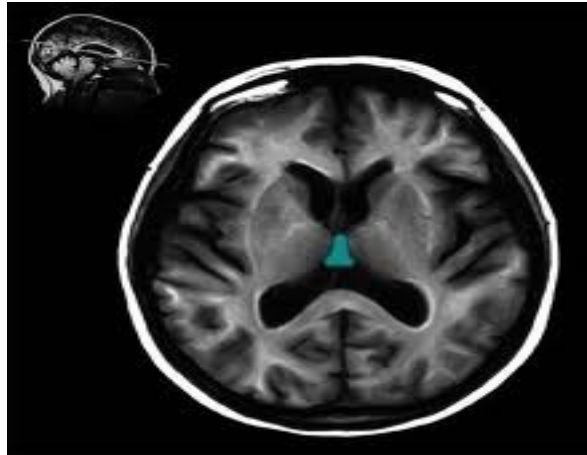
Axial MRI T1 of third ventricle
